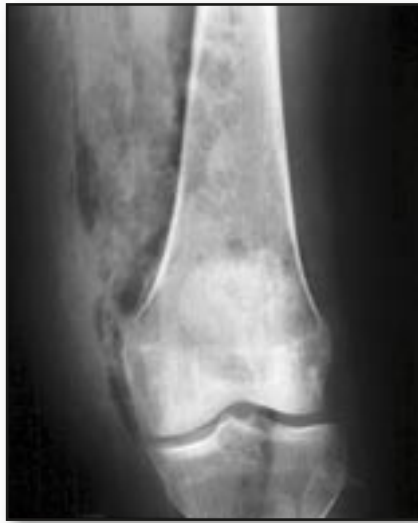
(patient 6). X-ray of the distal left femur showing air in the soft tissues, which is suggestive of necrotising fasciitis.
